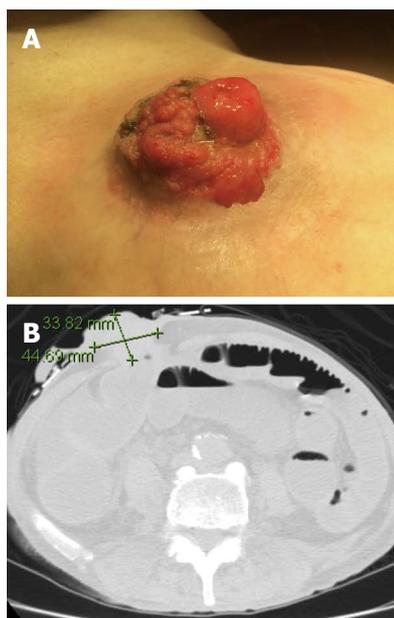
Physical exam (A) and computed tomography scan with measurements (B) of the parastomal mass.
